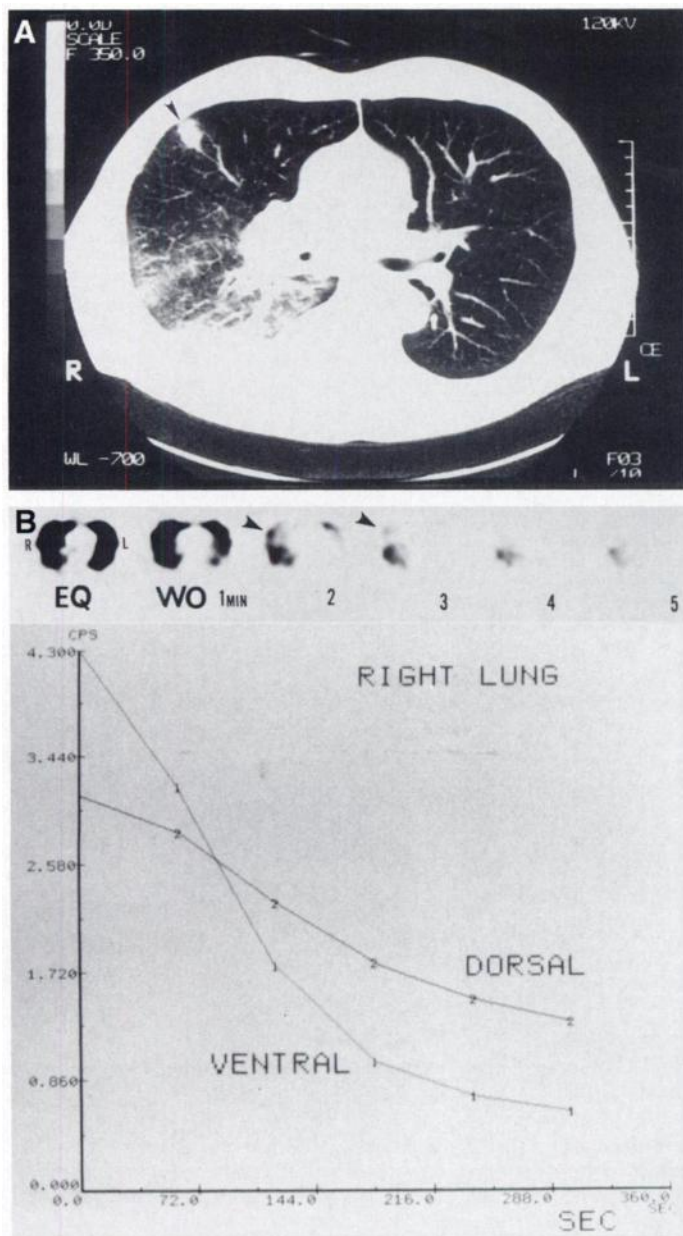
(A) Chest CT scan from a 63-yr-old man with lung cancer shows a right hilar tumor with secondary change in right lower lobe and an inflammatory small opacity in middle lobe (arrowhead). Fiberoptic bronchoscopy shows stenosis in lower and middle lobe bronchi. (B) SPECT shows ^{133}Xe activity on equilibrium image and prolonged ^{133}Xe washout in right lower lobe. Retention is also seen near the small opacity (arrowheads) (above). Washout curves in right lung show more prolonged $T_{1/2}$ (222.9 sec) in dorsal portion than ventral portion (104.7 sec) (bottom). (C) MTT image shows prolonged MTT in right dorsal portion and near the small opacity (arrowhead).
